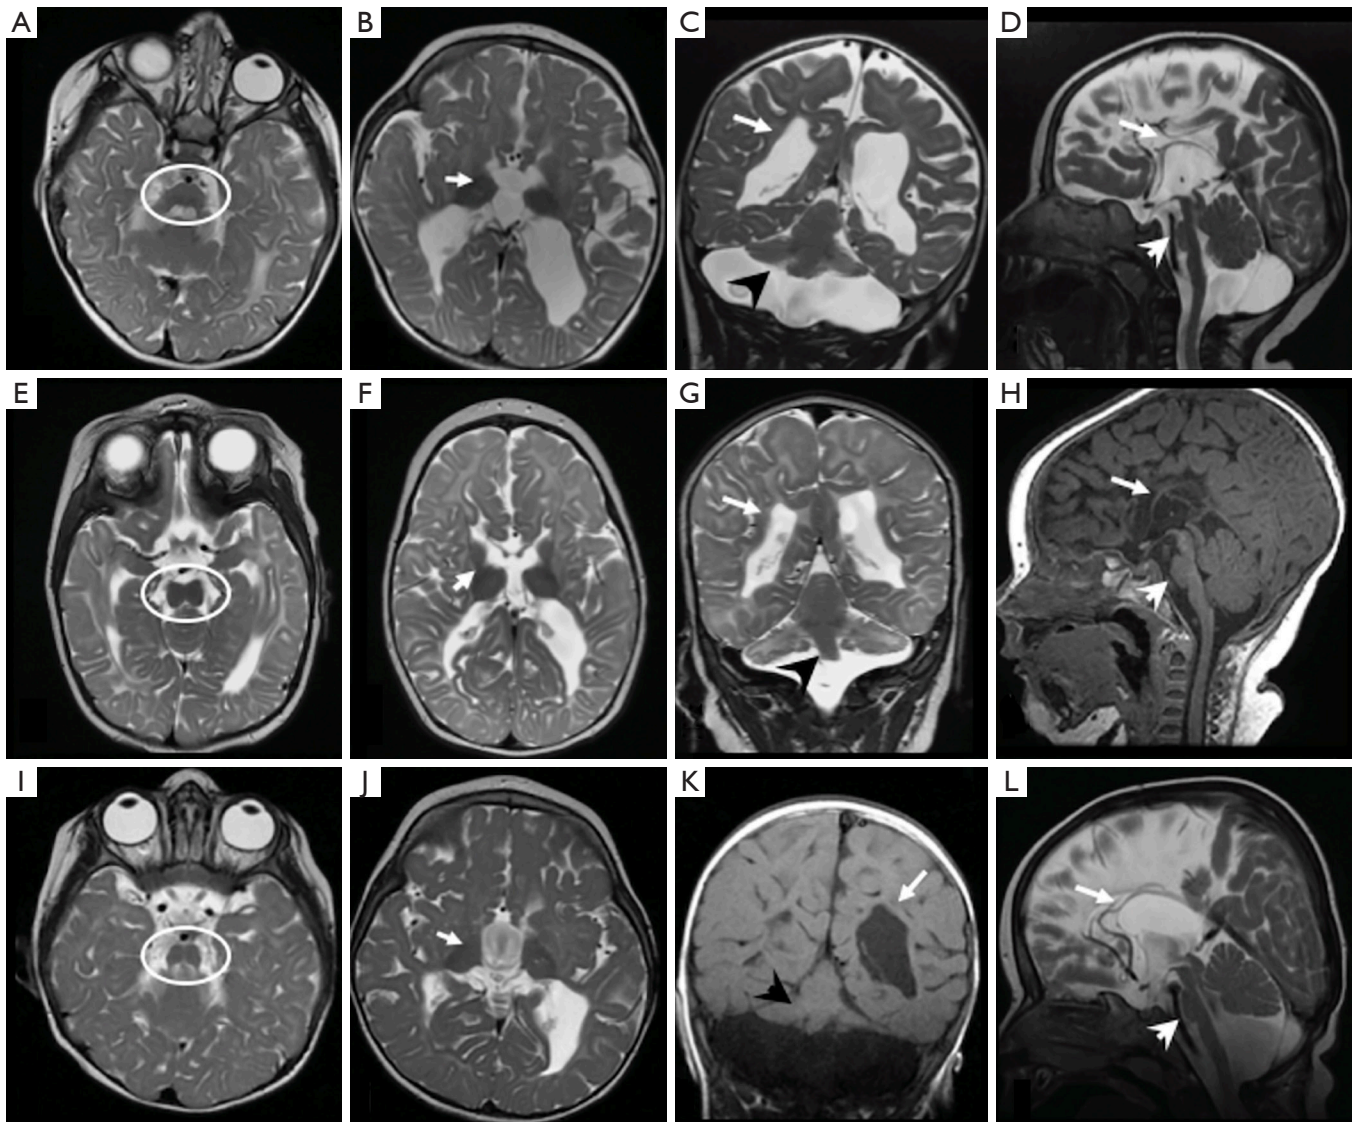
Brain MRIs from patient 1 (A-D), patient 2 (E-H) and patient 3 (I-L) with pontocerebellar hypoplasia 9. Axial T2-weighted images (A,B,E,F,I,J) show characteristic “figure of 8” midbrain appearance (white ovals) and small basal ganglia and thalami (white arrows). Coronal images (C,G,K) reveal hypoplasia/atrophy of the cerebellar hemispheres with relative sparing of the vermis (dragonfly appearance—black arrowheads), periventricular leukomalacia and enlarged lateral ventricles (white arrows). Sagittal T1 and T2-weighted images (D,H,L) show small pons (white arrowheads) and extreme thinning of corpus callosum (white arrows). MRI, magnetic resonance imaging.
